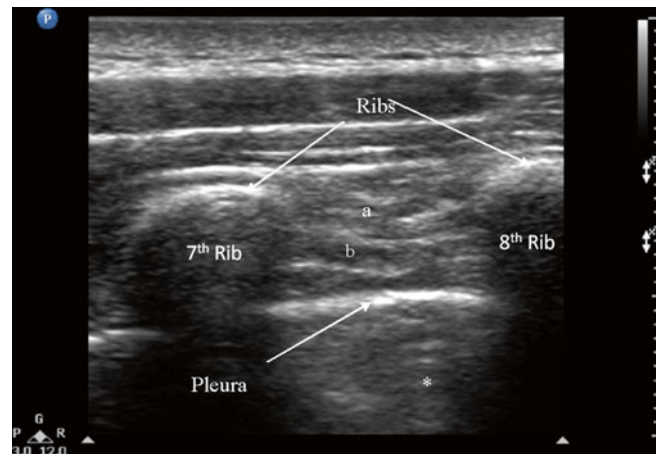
Ultrasonographic image showing the intercostal muscles and pleura at the angle of rib. *a* external intercostal muscle, *b* internal intercostal muscle, * reverberation artifact. The pleura appears as a hyper-echoic line (Reproduced with permission from Philip Peng Educational Series)
